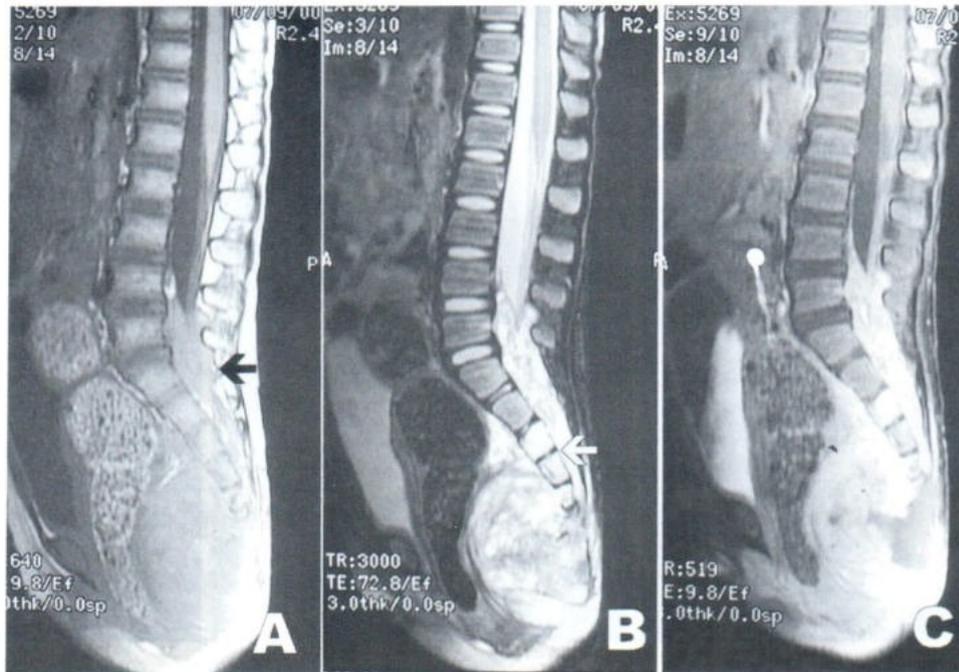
Endodermal sinus tumor. Sagittal T1-weighted image (A) shows a slightly hyperintense mass compared to muscle in the retrorectal space with invasion of the spinal canal (black arrow). On sagittal FSET2-weighted image with fat suppression (B), the mass is mixed hyper- and hypointense. Abnormal hyperintensity of the S3-S5 (white arrow) and destruction of S5 and coccyx are seen. Postcontrast sagittal T1-weighted image with fat suppression (C) shows heterogeneous enhancement of the mass and abnormal enhancement of S3-5.
